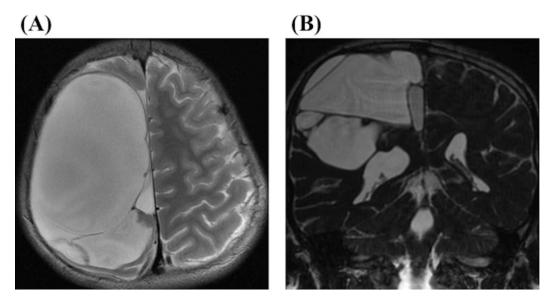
An 11-year-old boy manifested mild hemiparesis presented with interhemispheric arachnoid cyst with multiple cystic components on MRI (A; axial section on T2 WI and B; coronal section on FIESTA). His symptoms improved after endoscopic fenestration between multi-cyst components.
